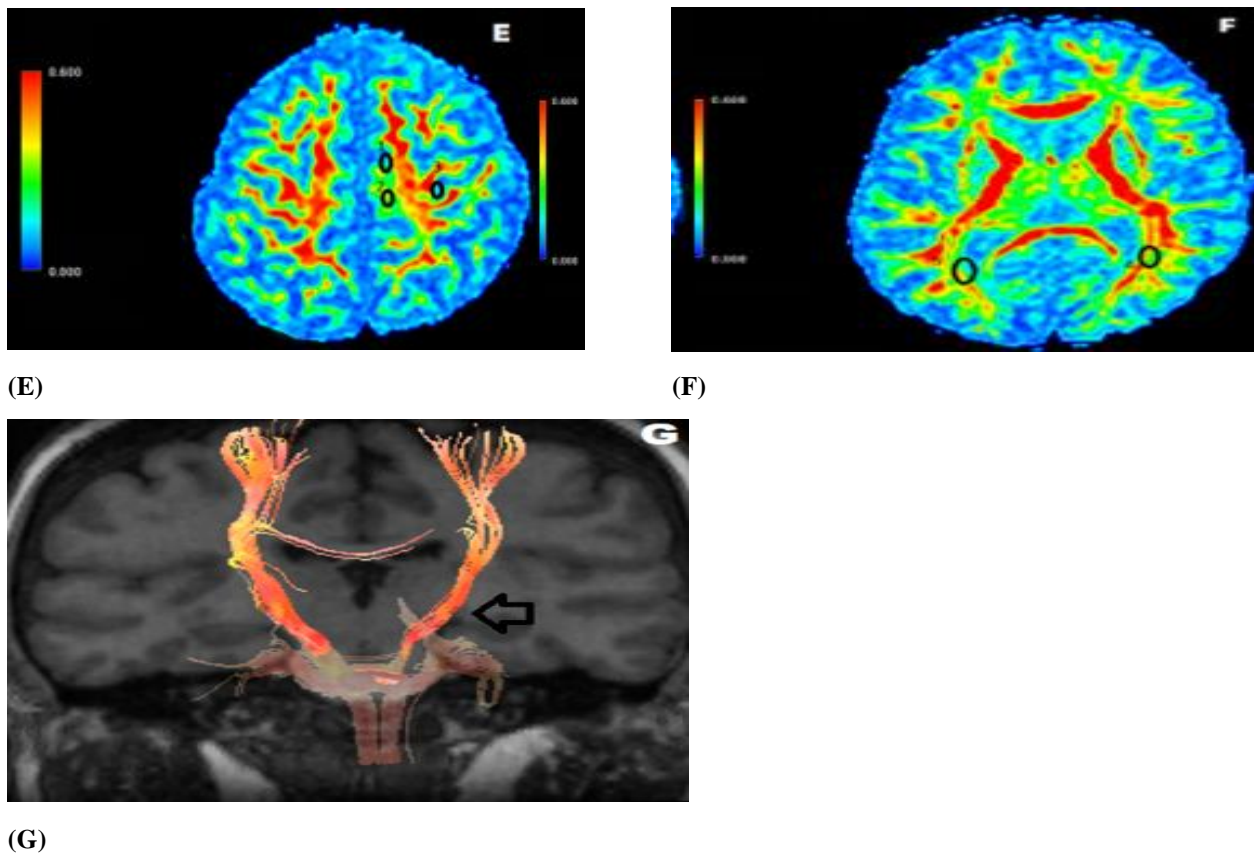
Axial FLAIR (A-B) multiple foci of hyperintense signal in left high parietal and deep periventricular close to both occipital horns of lateral ventricle, (C-D) diffusion weighted images showed no diffusion restriction, fraction anisotropy map (E-F) showed five region of interests were drawn on the hyperintense foci which were noted on FLAIR images with affection of diffusion tensor imaging parameters and corticospinal tractography (G) showed decrease in fiber density of left corticospinal tract in comparison to right side, fractional anisotropy 0.456
